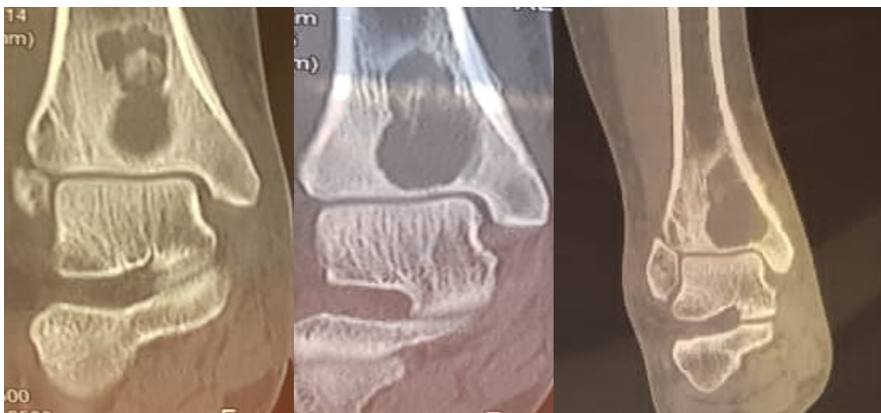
Pretreatment CT scans of the ankle and foot (coronal bone window) shows multiple intraosseous cystic lesions with sclerotic, well-defined margins with narrow zone of transition in tibia, calcaneum, talus and many tarsal bones.
